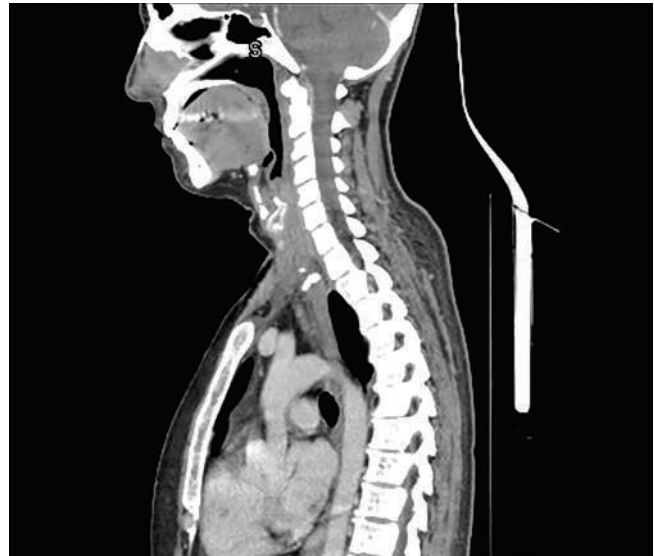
Cervical esophageal transection following thyroidectomy: computed tomography imaging of proximal esophagostomy and stapled distal esophageal closure.
